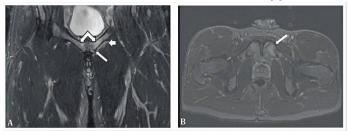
Sagittal (A) and Axial (B) T2 weighted MR images displaying bilateral bone edema.
